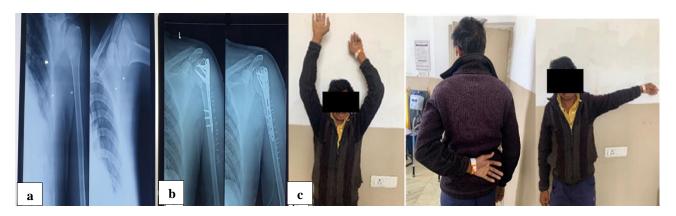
Case of 35-year-old male H/O fall from bike operated with PHILOS platting using the delto-pectoral approach (a) pre-op X-ray; (b) post-op X-ray; and (c) active forward flexion at 6 months. Post-operative outcome according to constant score at 6 months: good, complications: none.
